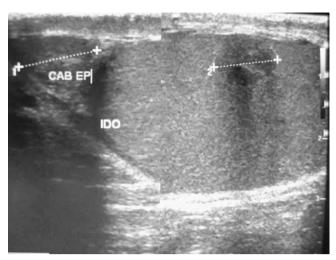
Testicular ultrasound showing a hypoechoic node with regular borders and posterior acoustic shadowing.
